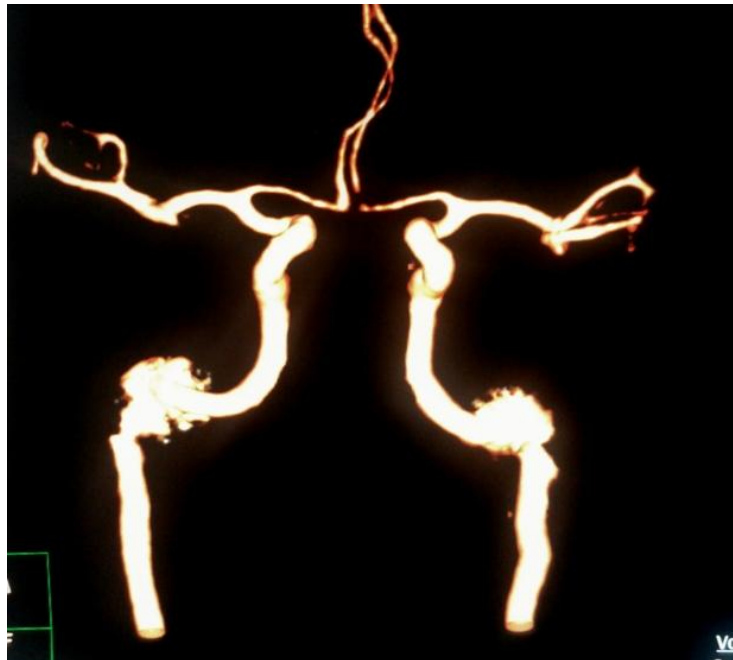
Volume rendered post processed CT angiography image shows the bilateral ICA aneurysms
